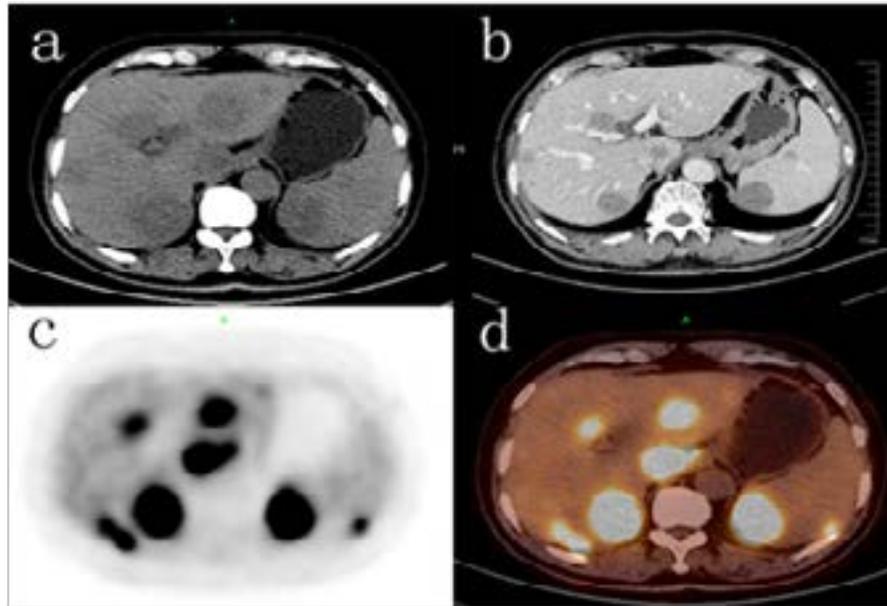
Computed tomography images showed multiple low-density lesions in liver and spleen (a) with mild capsular enhancement after intravenous contrast media (b). The positron emission tomography revealed increased FDG uptake in the lesions of liver and spleen (c, d).
